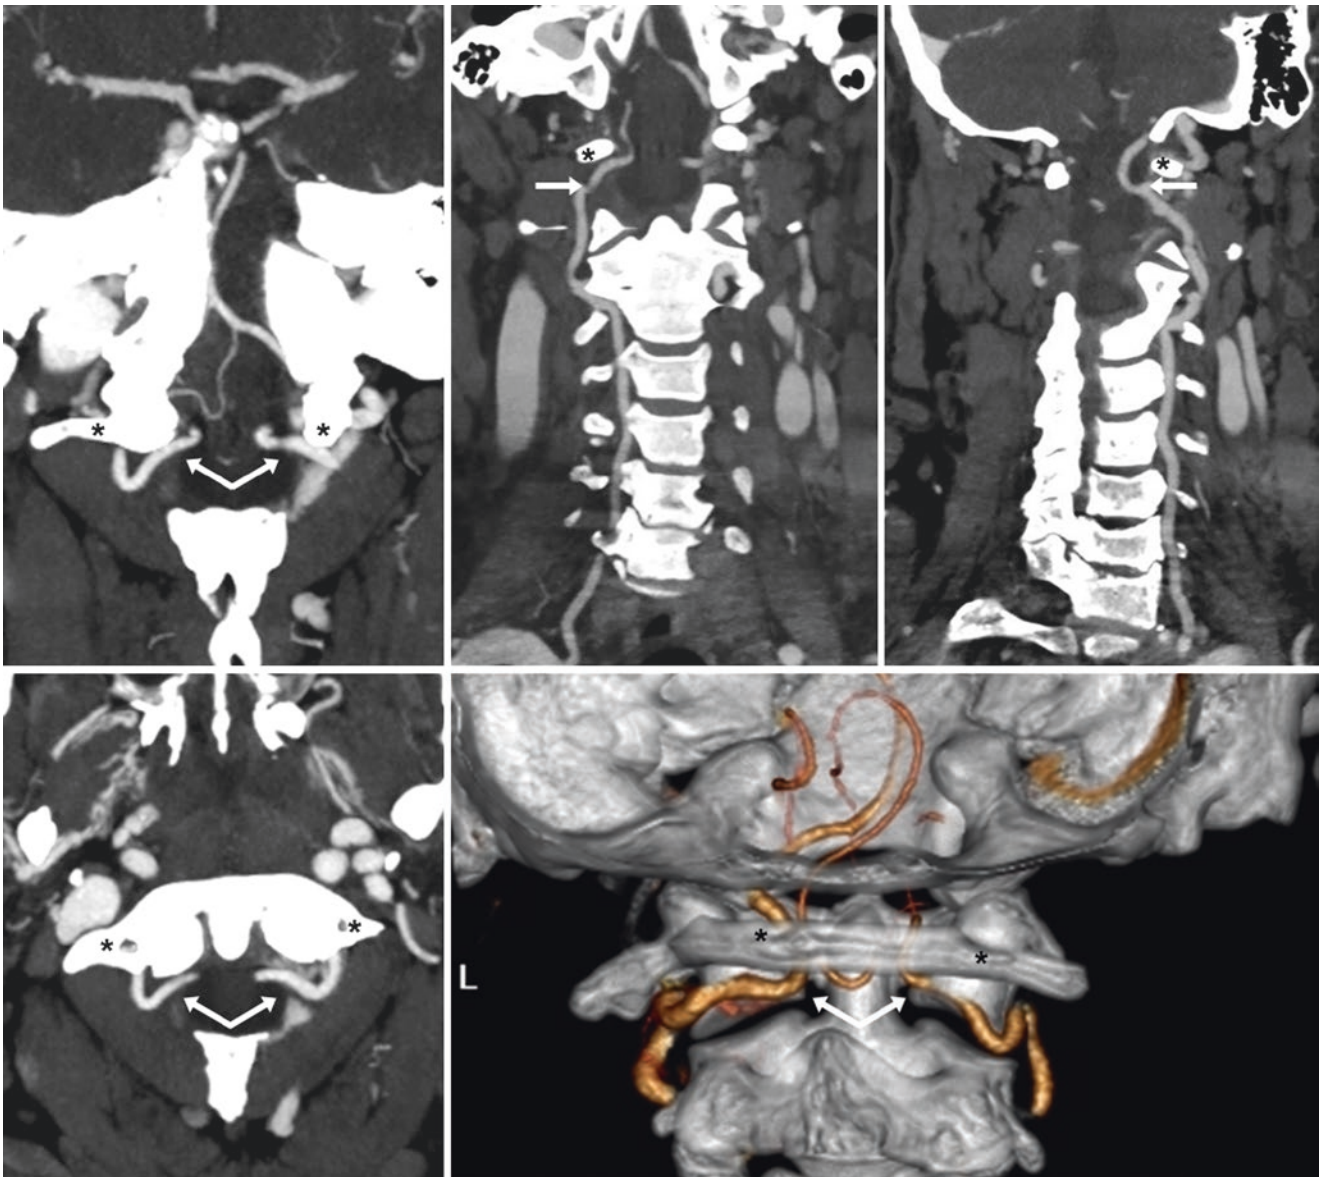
In a 44-year-old with trauma and altered mentation (no cervical spine fracture), a CTA demonstrated anomalous entry of the V4 segments of both VAs into the dura (*arrows*) just below the level of C1 (*asterisks*), on coronal MPR (*top left*), curved coronal MPR of the right
